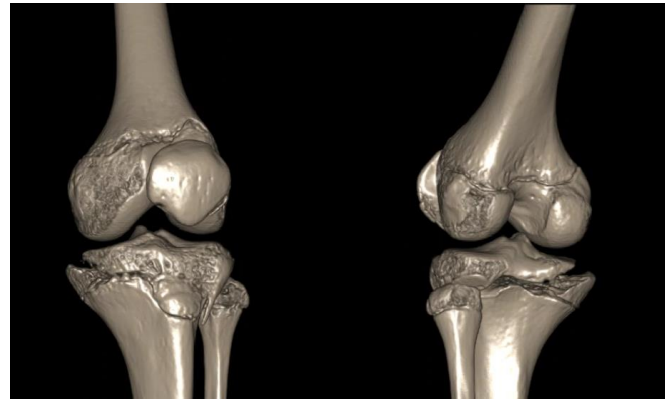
3D Trauma CT Scan of the left knee showing proximal tibia fracture with salter Harris type III..
